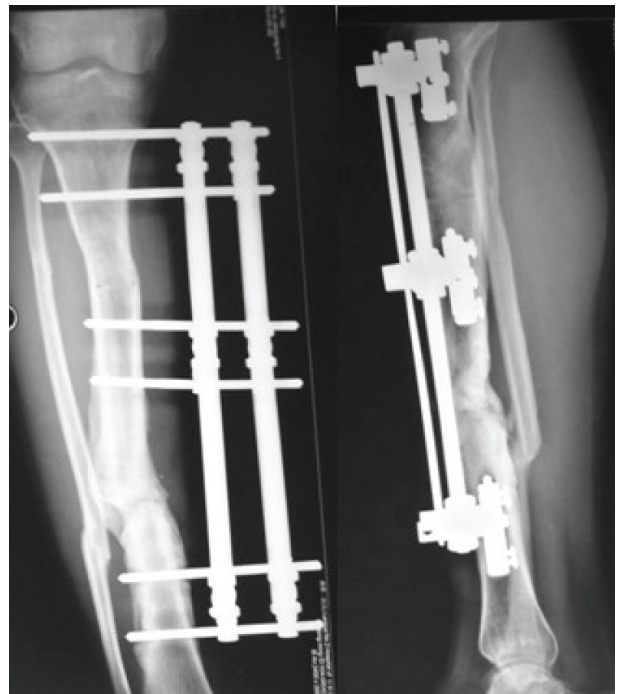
After 8 months of the compression and distraction, the radiograph shows good consolidation of the regenerate and bone union at the docking site.
